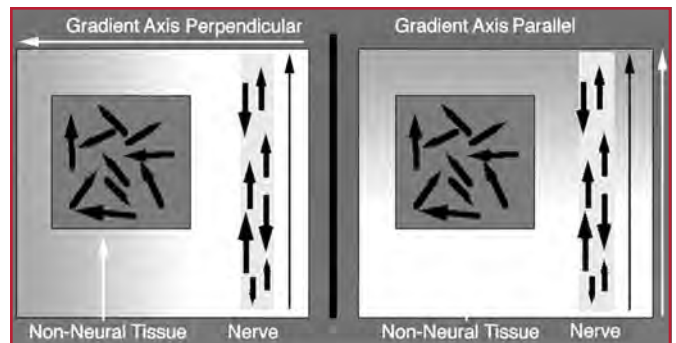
Isotropic and anisotropic diffusion of water molecules in diffusion magnetic resonance imaging. Shades of gray intensity indicate the intensity of the magnetic field, which varies across the image plane because of the imposed pulsed magnetic field gradient. Water diffuses in all directions in most nonneural tissues (isotropically) but diffuses preferentially along the long axis of nerves (anisotropically). When all of the water molecules in a tissue experience identical magnetic field strength despite diffusion movements, the magnetic resonance signal from that tissue remains bright relative to the signal decay in surrounding isotropically diffusing tissue water. This is the situation on the left where the magnetic gradient is oriented perpendicular to the nerve. In the situation on the right, the water molecules in nerve move preferentially to different positions in the gradients more rapidly than in the nonneural tissue so that the signal remains brighter from nonneural tissue.
